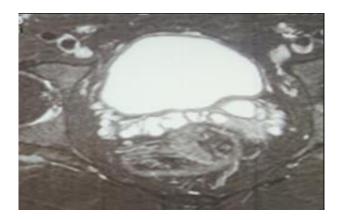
MRI contrast confirming a seminal vesicle cyst.
